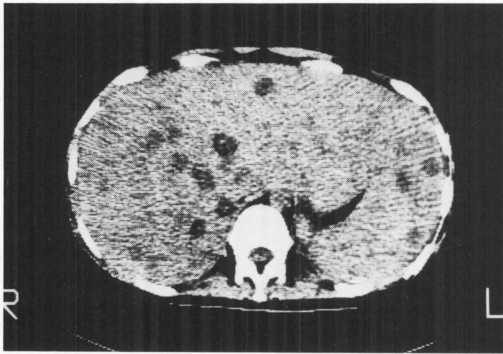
Case 2, A 23-year-old woman with ALL. A. Initial unenhanced CT demonstrates multiple lesions with decreased attenuation in the liver and spleen.
